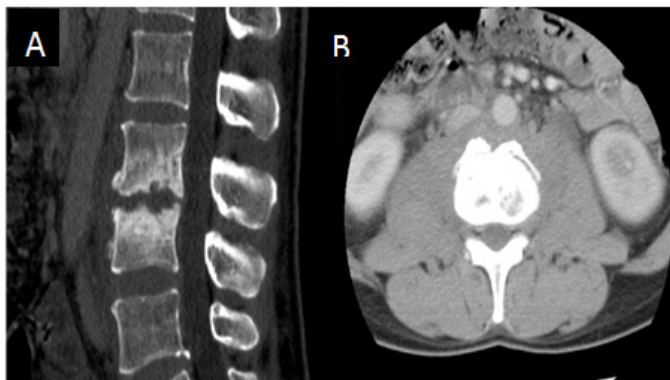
CT of the spine showing endplate sclerosis and irregularity (A). Mildly enhanced soft tissue between the spine and abdominal aorta (B).
